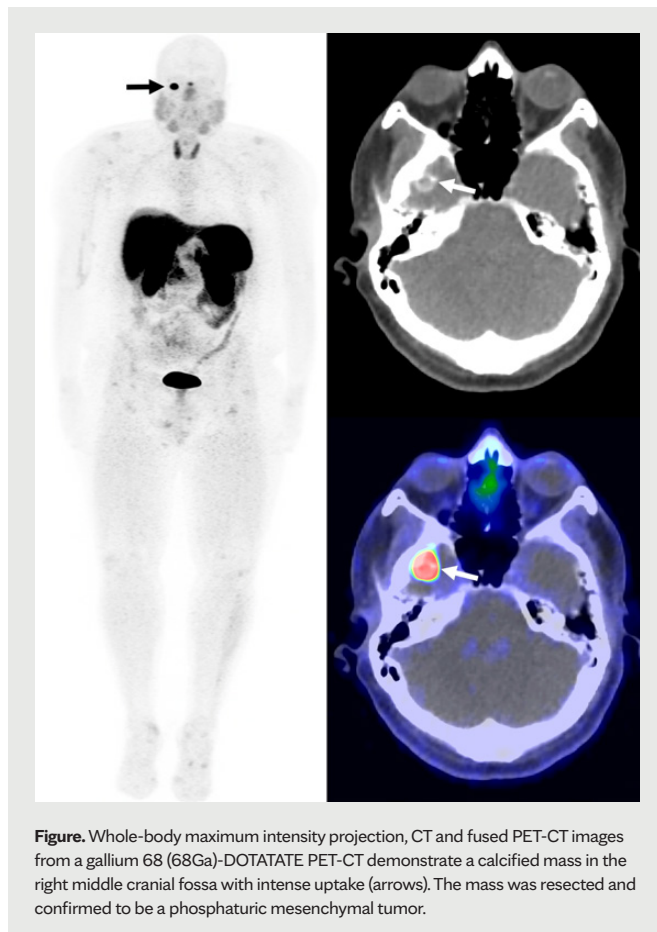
Whole-body maximum intensity projection, CT and fused PET-CT images from a gallium 68 (⁶⁸Ga)-DOTATATE PET-CT demonstrate a calcified mass in the right middle cranial fossa with intense uptake (arrows). The mass was resected and confirmed to be a phosphaturic mesenchymal tumor.
